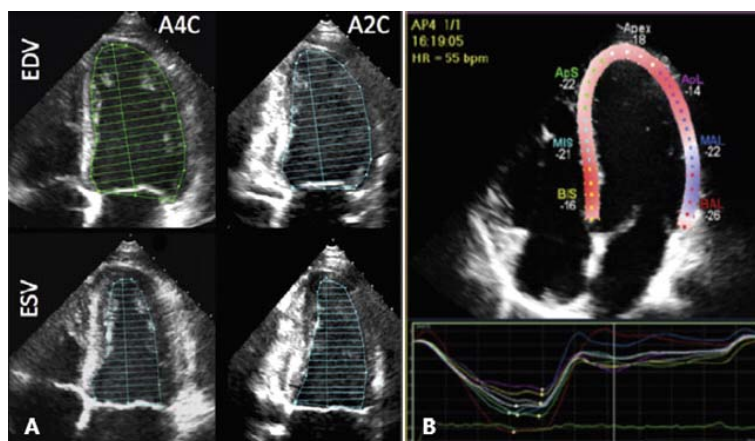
Main parameters of the left ventricular global systolic function. A – LV ejection fraction using biplane Simpson method; B – LV longitudinal strain in apical 4-chamber view. Adapted from [11]
